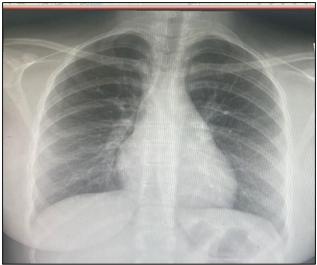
Chest X-ray: Regression of right lower zone opacity
